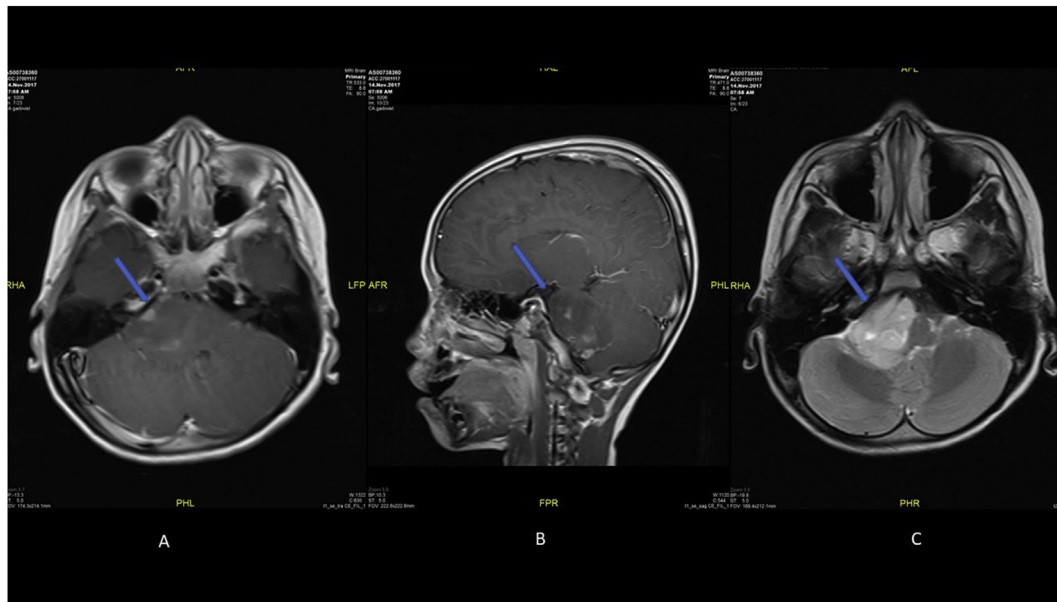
CPA mass arising from the right side of pons and cerebellar peduncle occluding the porus acusticus and causes mass effect onto the 4th ventricle. The axial (A) and sagittal view (B) of the T1-weighted post contrast images showing a well-defined heterogeneous solid mass at the right CP angle with only small areas of enhancement post-contrast. The T2-weighted image (C) shows enhancement of the lesion with areas of hypertense signal suggestive of a cystic component. There is also evidence that the mass has abutted the basilar and right vertebral artery. The arrows point to the lesion.
